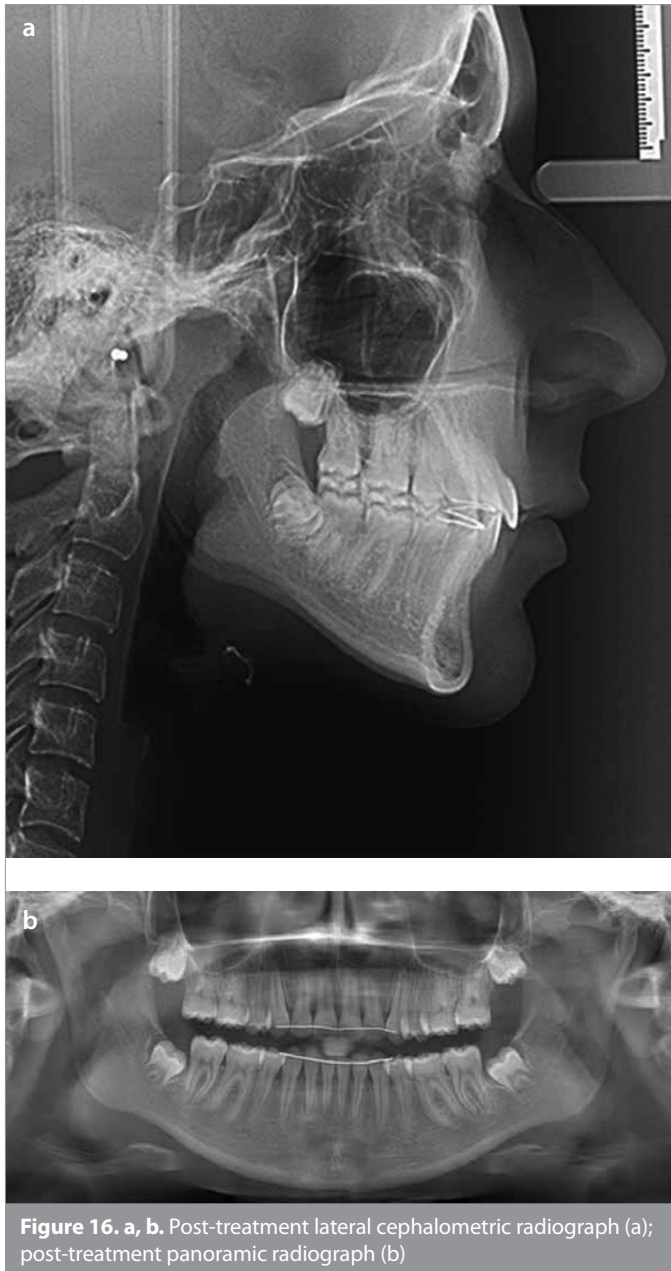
a, b. Post-treatment lateral cephalometric radiograph (a); post-treatment panoramic radiograph (b)
